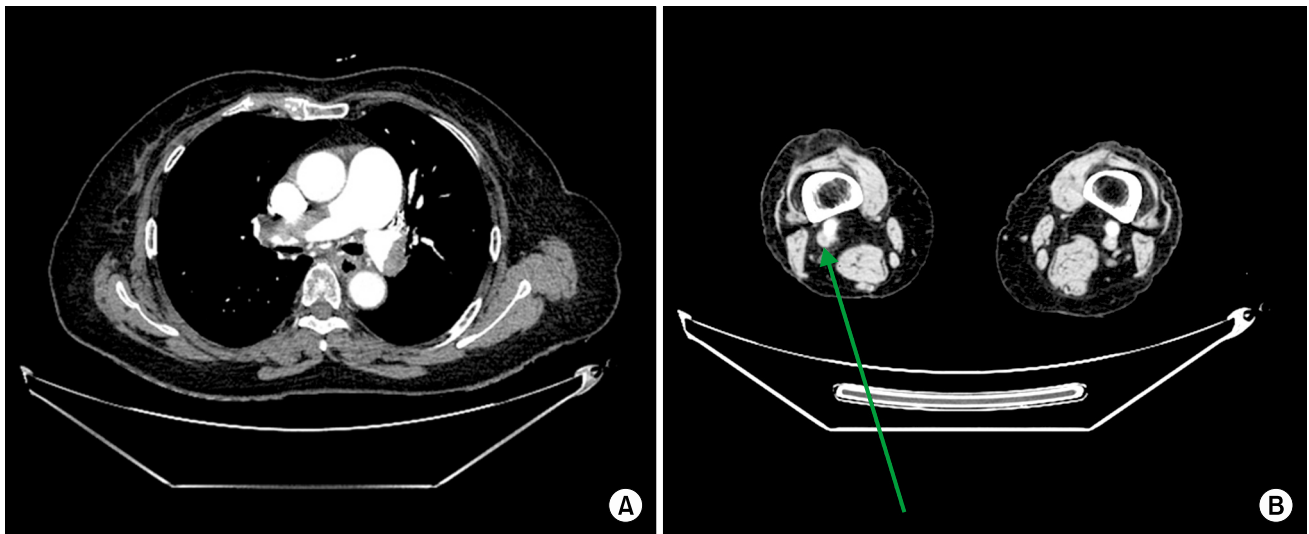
Axial computed tomography scan showing (A) extensive pulmonary thromboembolism obstructing the bilateral main pulmonary arteries and the branches and (B) deep vein thrombosis in the right popliteal vein (arrow).
